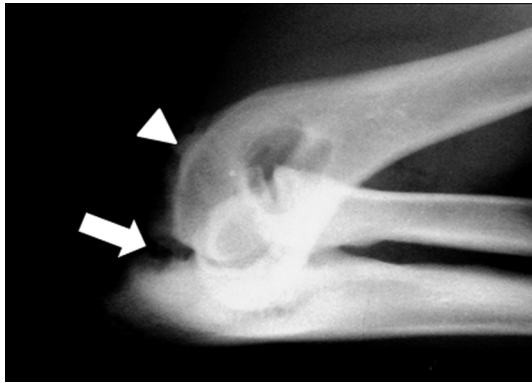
A lateral radiography of the flexed left elbow. A lucent, irregular line between and anconeal process and the olecranon (arrow) is revealed. The periarticular osteophyte (arrow head) along the humerus condyle is showed.
